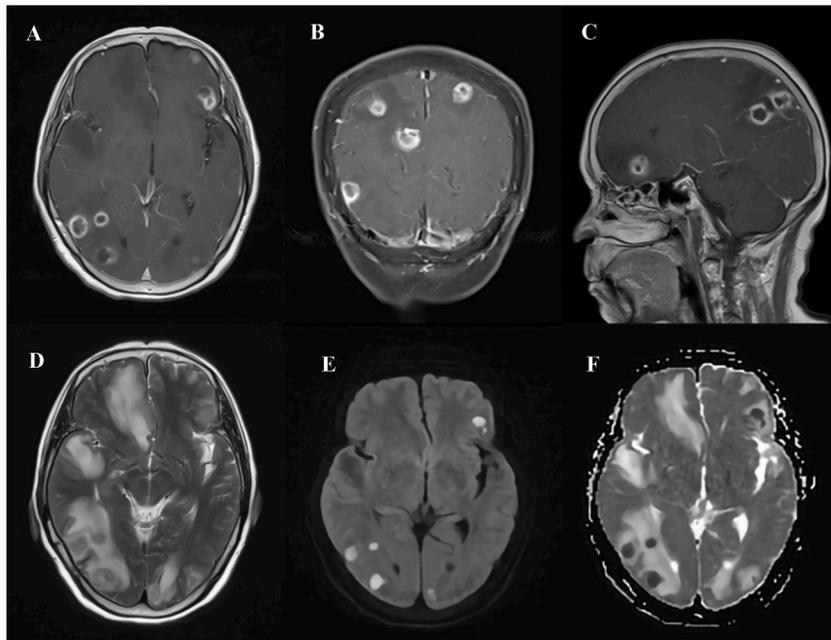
Contrast-enhanced MRI scans of this case revealed multiple lesions in the right cerebral hemisphere with irregular ring enhancement: A (T1W transverse axis), B (T1W coronal), C (T1W sagittal), and D (T2W transverse); E, exhibited high signal intensity on DWI; F, demonstrated low ADC values.
